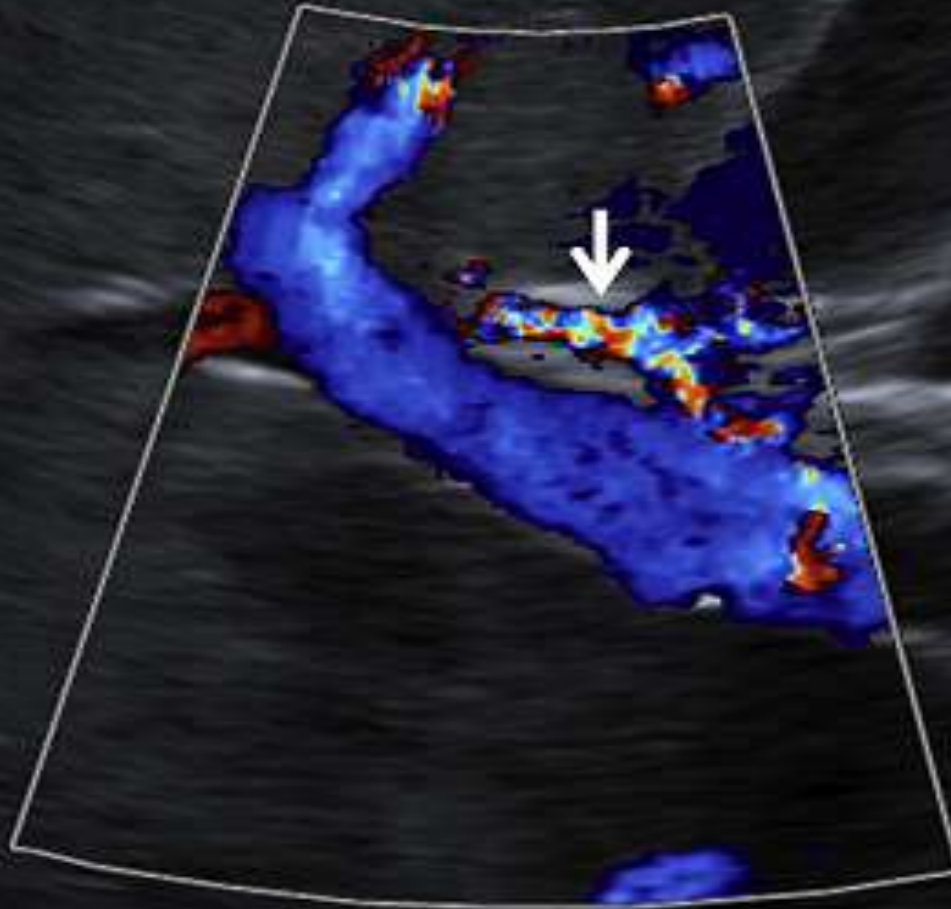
(A) Color Doppler of helical portal venous flow at the hepatic hilum. Flow is antegrade, but appears as alternating red and blue spiral bands (B). This appearance should not be confused with hepatofugal flow.
